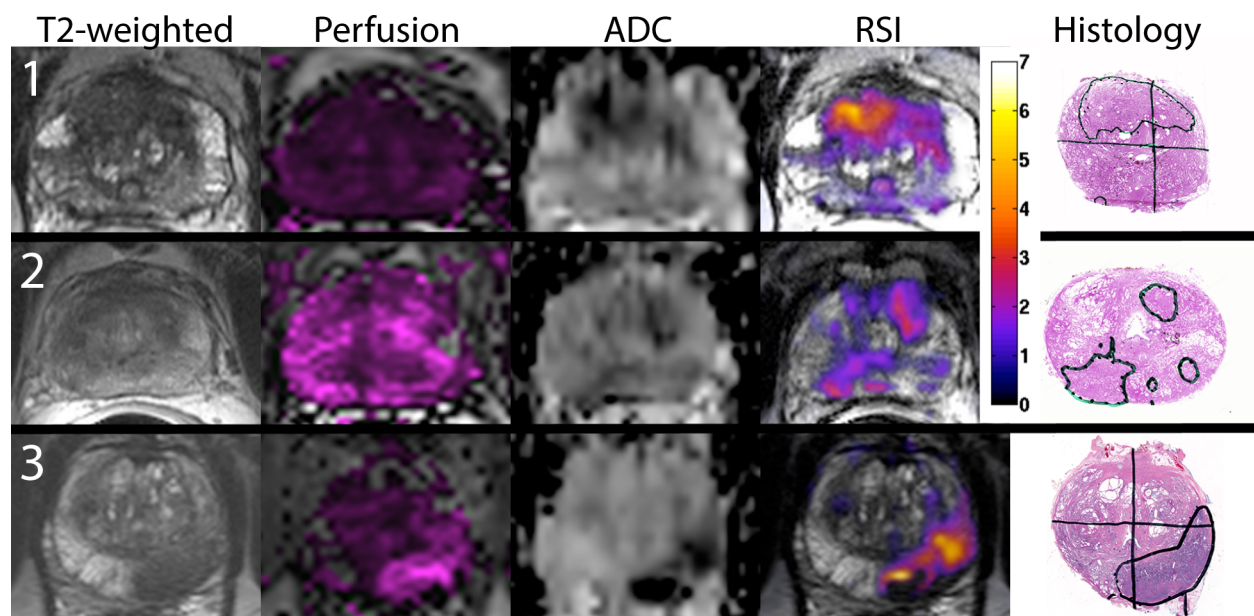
MR imaging and whole mount pathology for 3 prostate cancer patients without EPE. Column 1: T2 – weighted images, column 2: Perfusion K_{trans} maps, column 3: standard apparent diffusion coefficient (ADC) maps ($b = 0, 100, 400, \text{ and } 800 \text{ s/mm}^2$), column 4: RSI z-score maps, column 5: whole mount pathology with tumor and area of EPE identified. Color bar represents zscores from 0 to 7 for the RSI maps.
